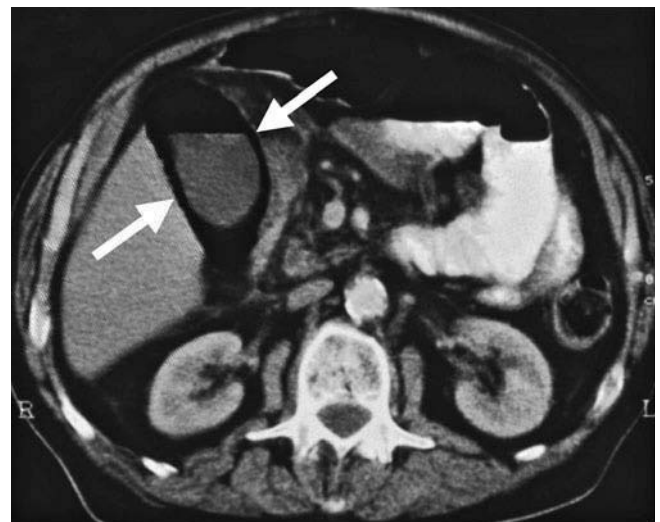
Diabetic patient with emphysematous cholecystitis and gangrene of the gallbladder. CT shows air-fluid level in the gallbladder lumen and air in the gallbladder wall (arrows)
